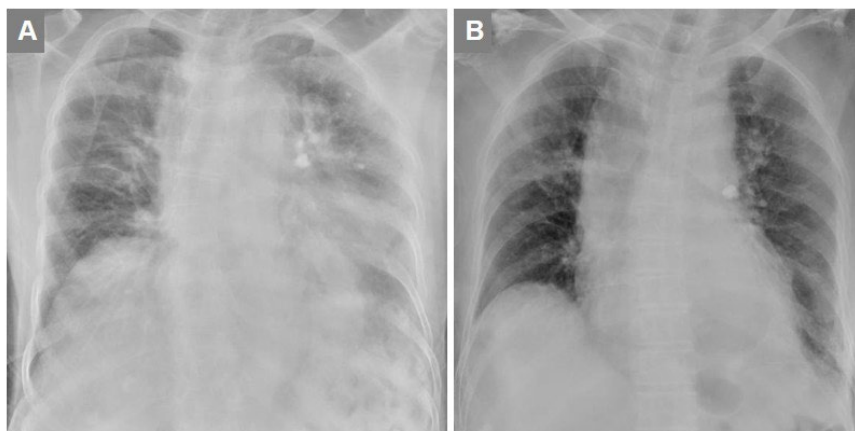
Chest X-ray. (A) On the admission day. (B) On the 16th day of hospitalization.
